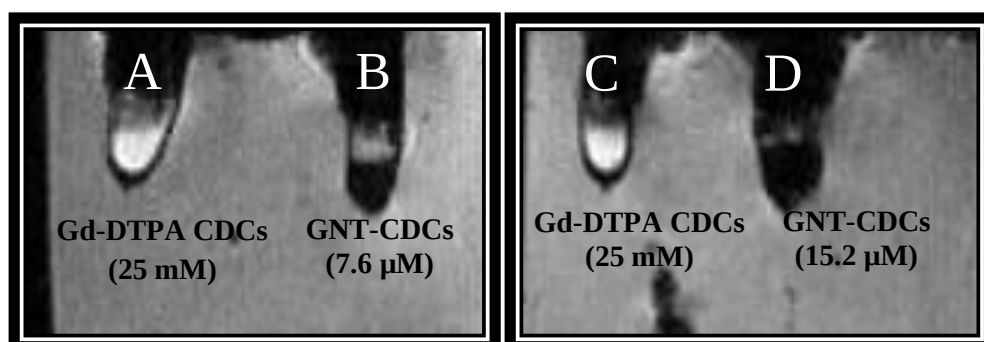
CDCs labelled with 7.6 μM and 15.2 μM gadonanotubes were pelleted at the bottom of 100 μl eppendorf tube and topped with 2% agarose in DMEM/F12 medium. However, CDCs labelled with gadonanotubes at both concentrations showed hypointense contrast on T1-weighted image. GNT; gadonanotubes ($n=1$).
